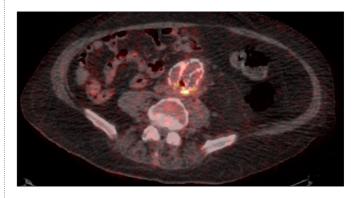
Positron-emission Tomography CT (CT-PET) showing an infected collection at the level of the bifurcation of the aorto-biliac graft. The graft is indicated by arrow A. There is a collection of gas posterior to the graft (arrow B) suggesting abscess formation with intense activity due to uptake of labelled fluorodeoxyglucose (FDG) seen on the edge of the abscess (arrow C).
